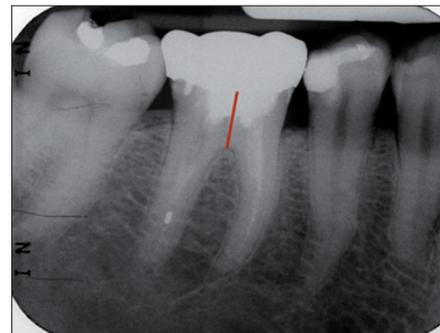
A periapical radiograph of a lower right first molar that was to be extracted. The tooth is root filled and the coronal portion heavily restored. One would anticipate the crown would readily fracture off during attempted removal. Sectioning the two roots as indicated by the red line will facilitate removal of the roots separately
